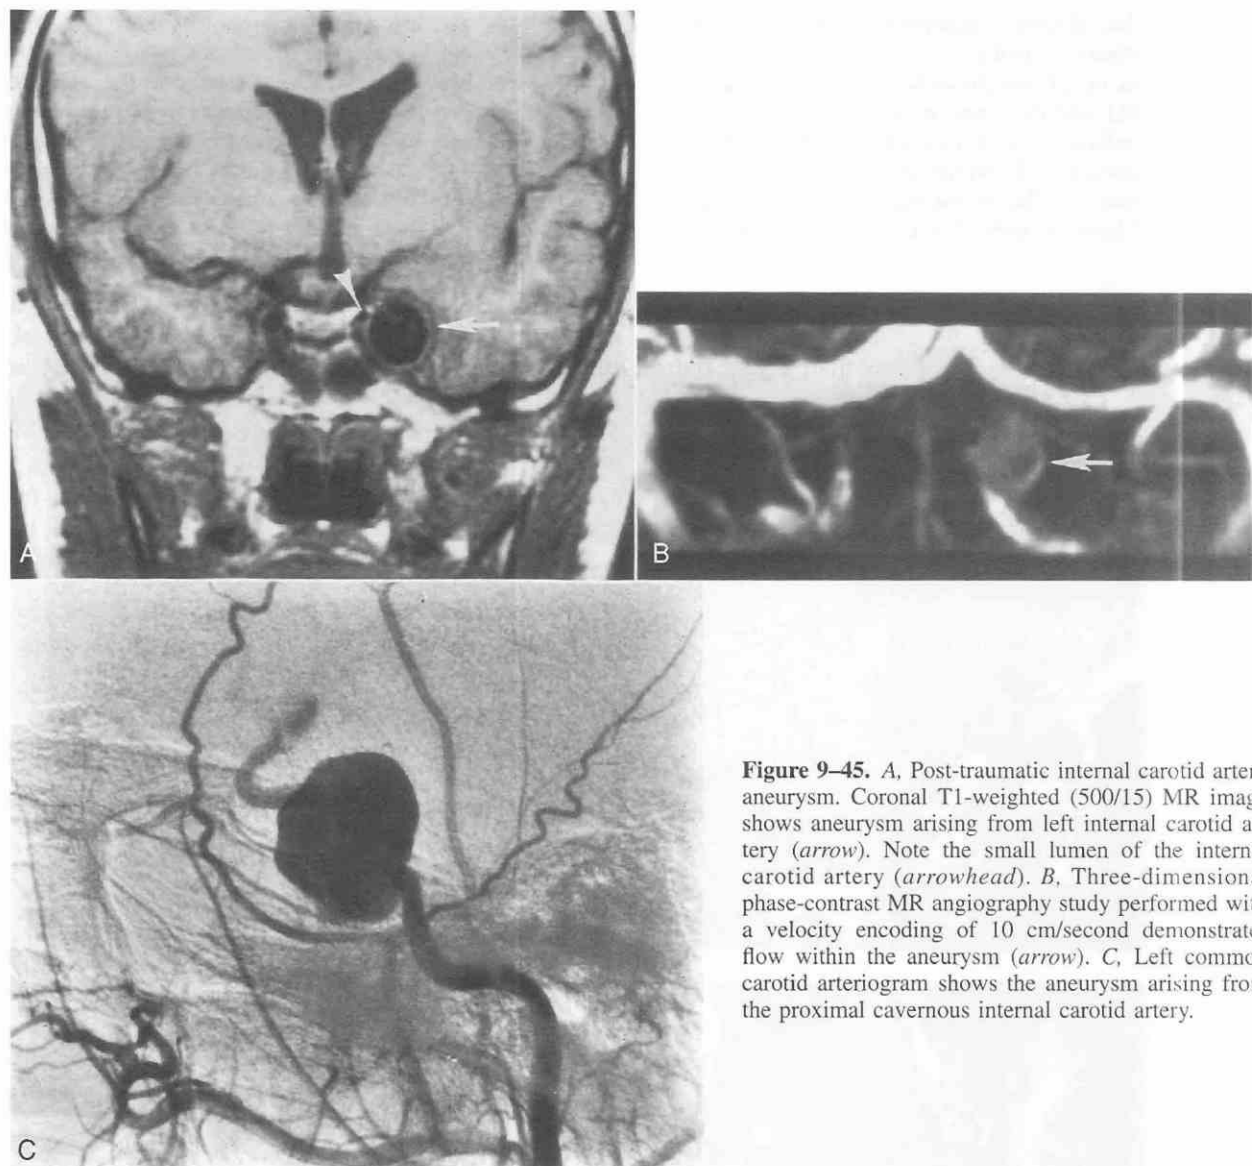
A, Post-traumatic internal carotid artery aneurysm. Coronal T1-weighted (500/15) MR image shows aneurysm arising from left internal carotid artery (arrow). Note the small lumen of the internal carotid artery (arrowhead). B, Three-dimensional phase-contrast MR angiography study performed with a velocity encoding of 10 cm/second demonstrates flow within the aneurysm (arrow). C, Left common carotid arteriogram shows the aneurysm arising from the proximal cavernous internal carotid artery.
